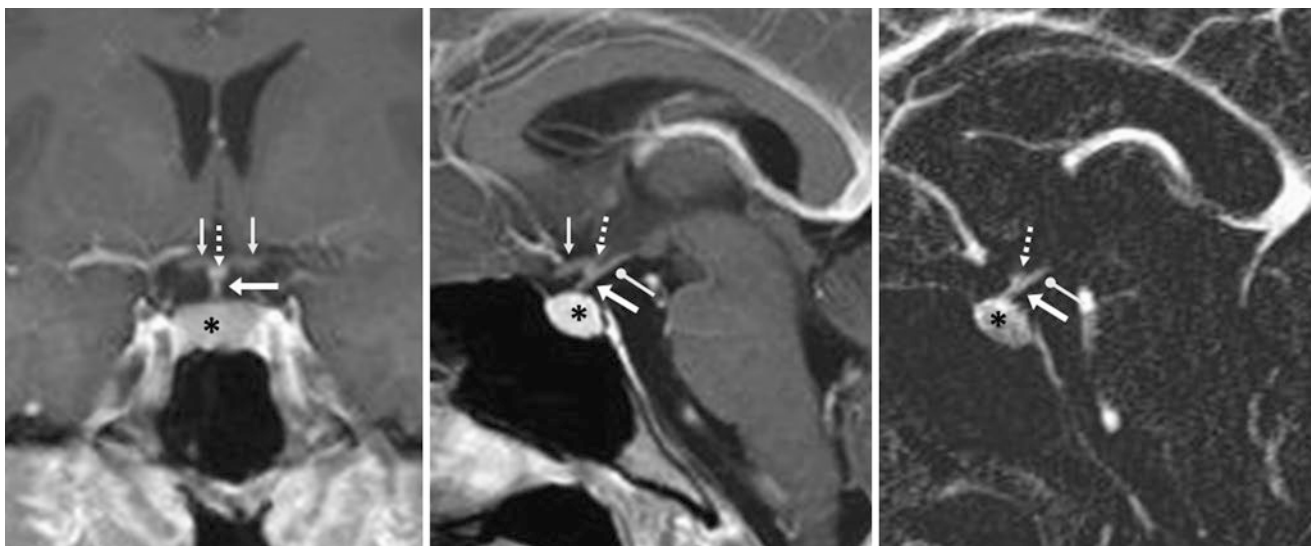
A 16-year-old female patient had a 1.5 T MRI that demonstrated a normal, enhancing pituitary infundibulum (*arrows*) relative to the nonenhancing optic chiasm (*thin arrows*). The pituitary (*) was normal and borderline enlarged because the patient was of childbearing age, as shown on postcontrast coronal (*left*) and sagittal T1WI (*middle*)
